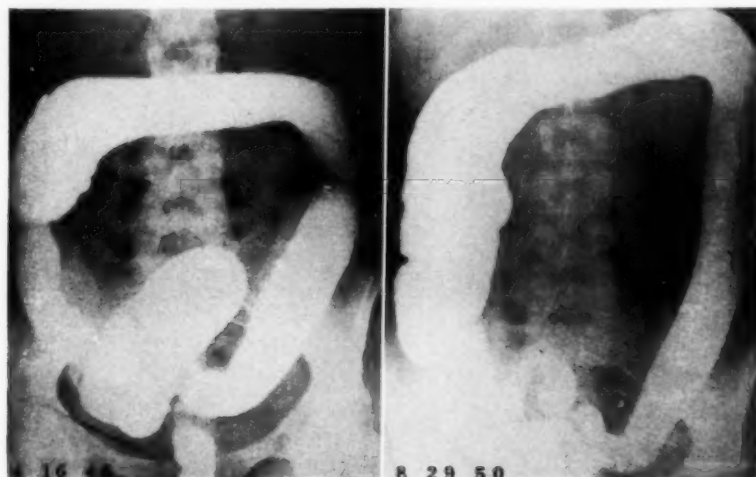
N. B. Improved though persistent roentgen evidence of colitis. Complete clinical recovery.
